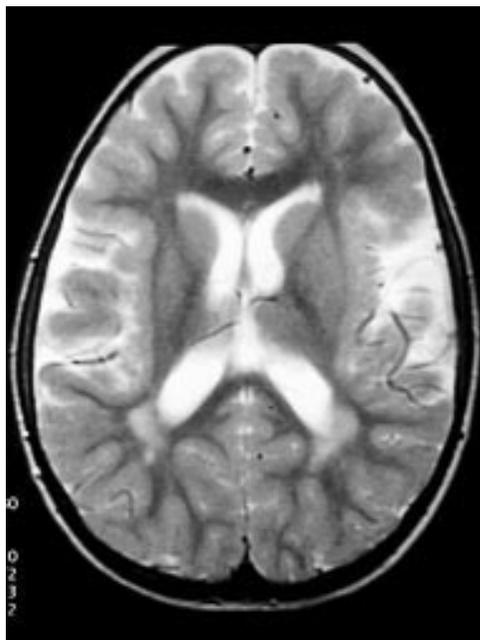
Cerebral MRI scan (T2 weighted image) of case 5 showing patchy areas of T2 hyperintensity of white matter, with focal cortical dysplasia.
